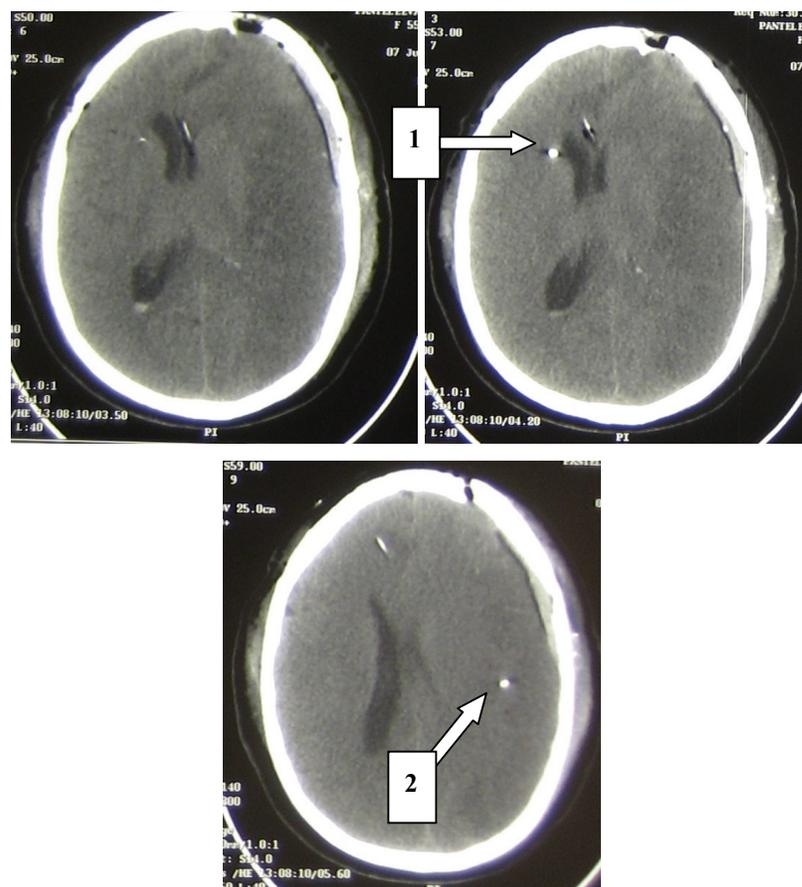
CT scan of the patient with vasospasm after left internal carotid artery aneurysm rupture. Microdialysis catheters are located in “intact” (1) and “lesioned” (2) brain tissue.
